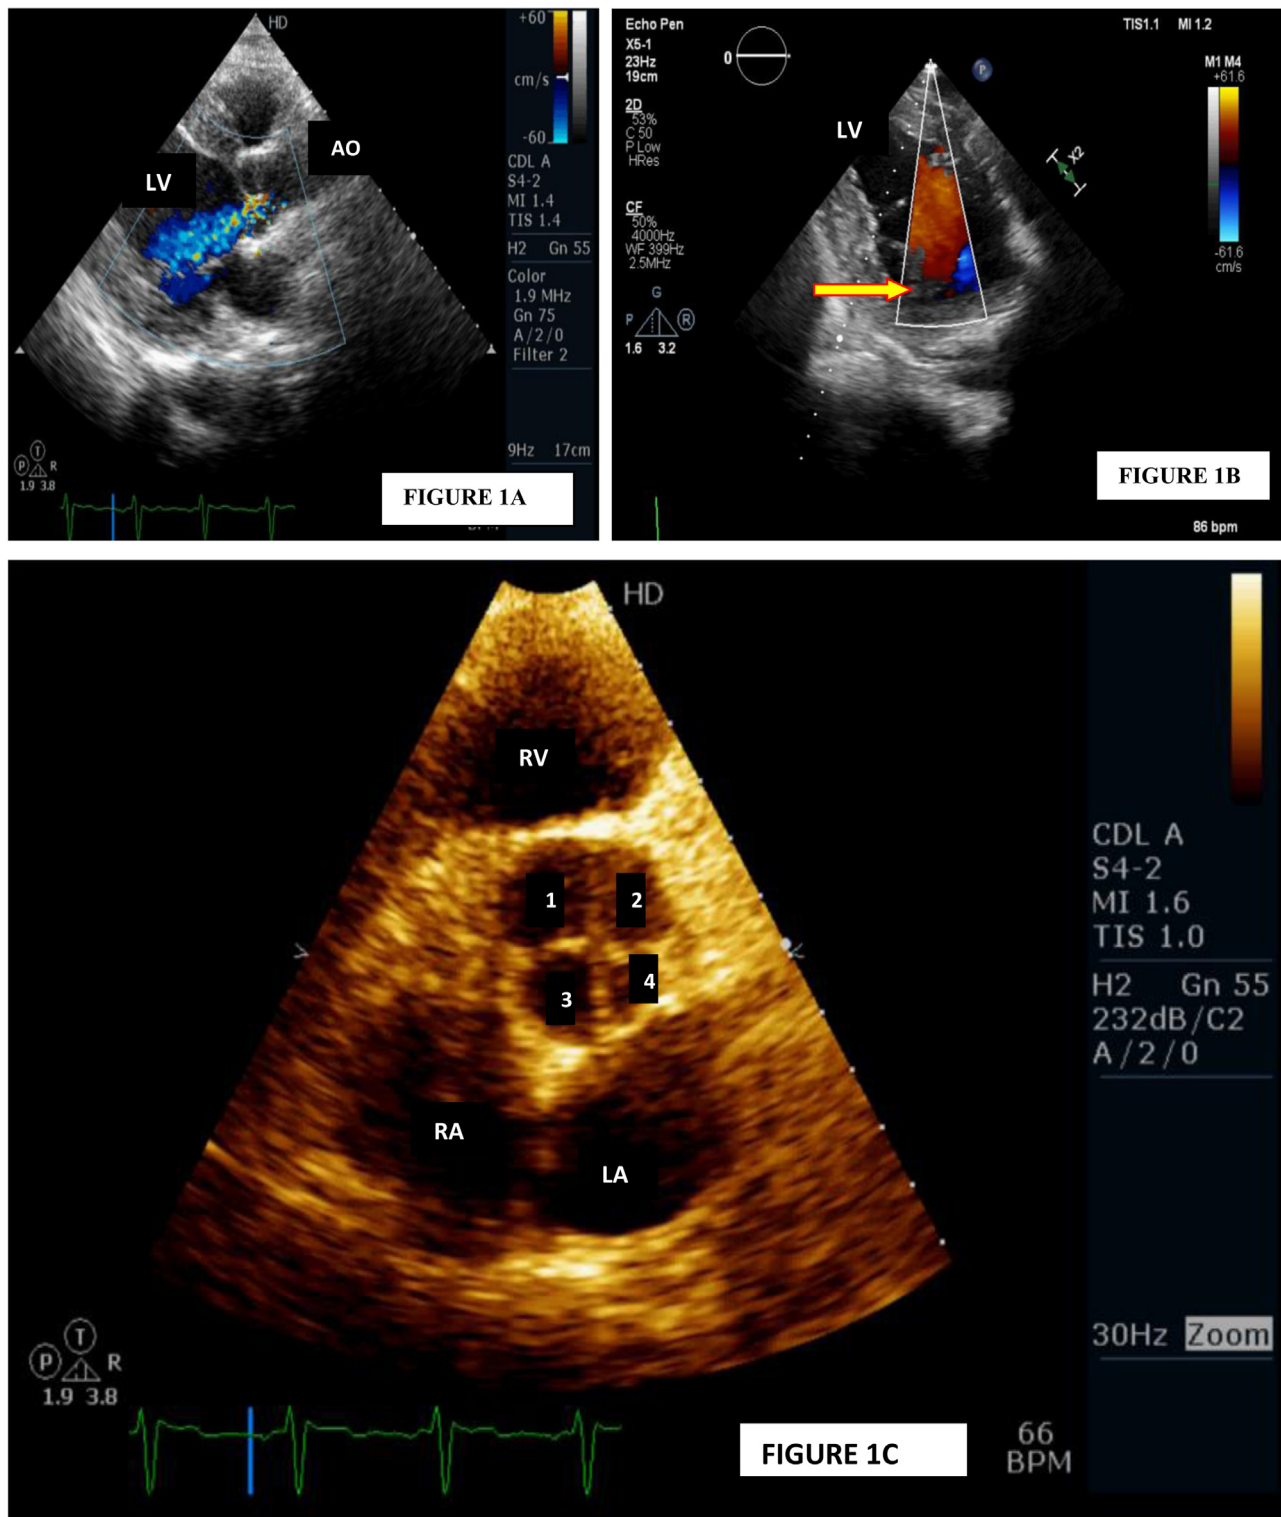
(A) parasternal long axis view showing moderate aortic regurgitation. LV: left ventricle; AO: aorta. (B) modified parasternal short axis view showing prominent trabecular recesses filling with blood (yellow arrow). LV: left ventricle. (C) parasternal short axis view at aortic valve level showing quadricuspid aortic valve. one large(1), two intermediate(2,3), one small(4) sized cusps- Hurwitz and Roberts type D. LA: left atrium; RA: right atrium; RV: right ventricle.
